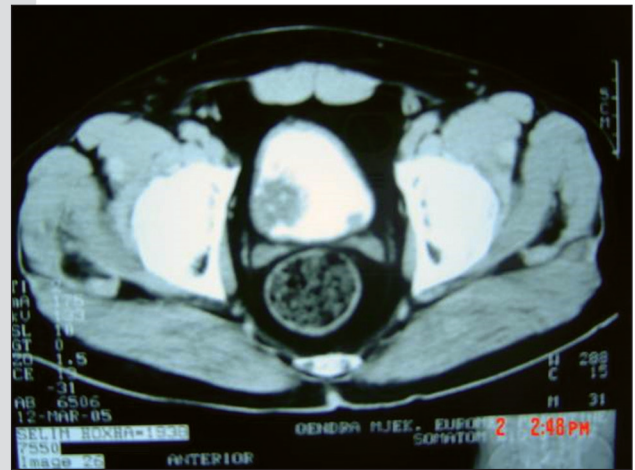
CT of the urinary bladder
